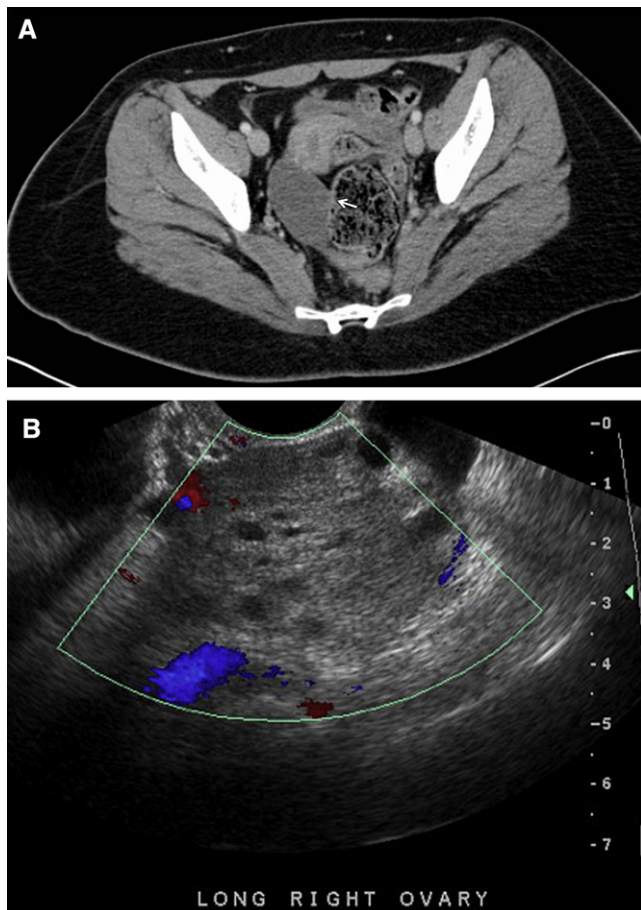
A 19-year-old patient with a history of polycystic ovarian syndrome, who presented with acute right lower quadrant pain. (A) Axial contrast-enhanced computed tomography, demonstrating an enlarged and relatively hypodense right ovary. There are several prominent follicles (eg, arrow) in the right ovary. (B) Subsequent transvaginal ultrasound, showing absent flow in an enlarged, heterogeneous right ovary that contains multiple predominantly peripheral follicles. Intraoperative findings confirmed torsion. This figure is available in colour online at <http://carjonline.org/>.
